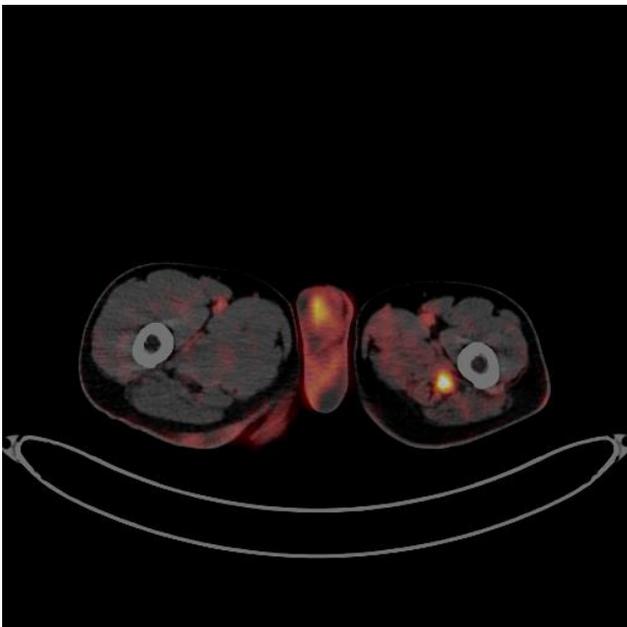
PET-CT. Diffuse hypermetabolism in the left sciatic nerve (maxSUV 8.32)
